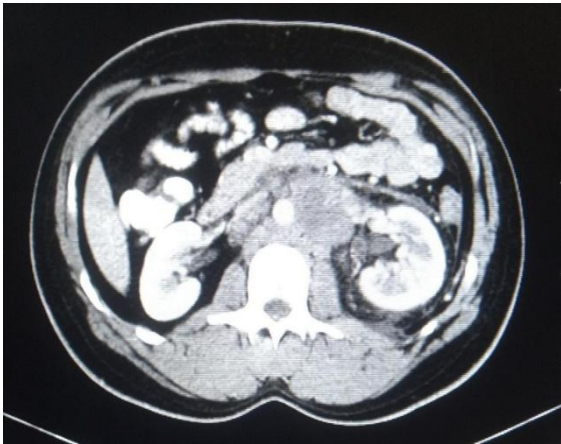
7 Transverse Image of CT scan abdomen
